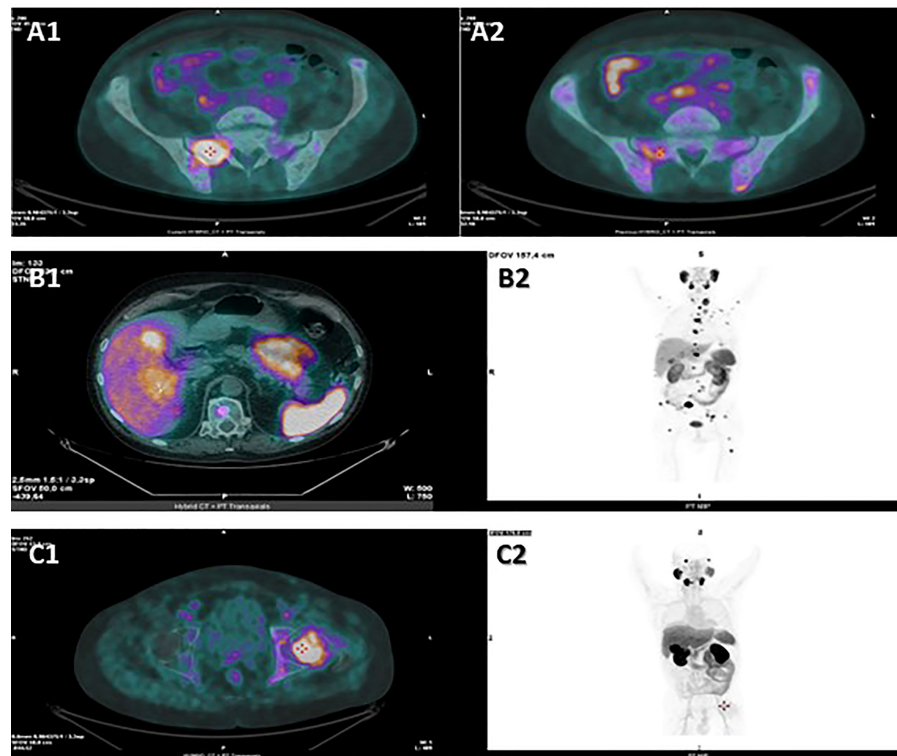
Hybrid CT + PET transaxial images from 18F-FDG PET/CT (A1) and from 18F-PSMA-PET/CT (A2) examinations performed by patient 1 in September 2021, hybrid CT + PET transaxial (B1) and PET MIP total-body (B2) images from 18F-PSMA-PET/CT examination performed by patient 2 in October 2021, hybrid CT + PET transaxial (C1) and PET MIP total-body (C2) images from 18F-PSMA-PET/CT examination performed by patient 3 in January 2022. PSMA-PET scan performed by patient 1 revealed an intense tracer uptake in the prostate and in several bone lesions, such as in the right ala of the sacrum (A2), while the hepatic lesions showed no tracer uptake. The following FDG PET scan revealed high FDG uptake in the liver and in several bone lesions, such as in the right ala of the sacrum (A1). PSMA-PET scan performed by patient 2 revealed high tracer uptake in the liver (B1, B2), bone (B2) and lymph nodes (B2). PSMA-PET scan performed by patient 3 showed tracer-avid foci in the prostate and in several osteoblastic lesions, such as in the left femur head (C1, C2), while no uptake was detected in the abdominal lymphadenopathies (C2). CT, computed tomography; PET, positron emission tomography; FDG, fluorodeoxyglucose; PSMA, prostate-specific membrane antigen; MIP, maximum intensity projection.
